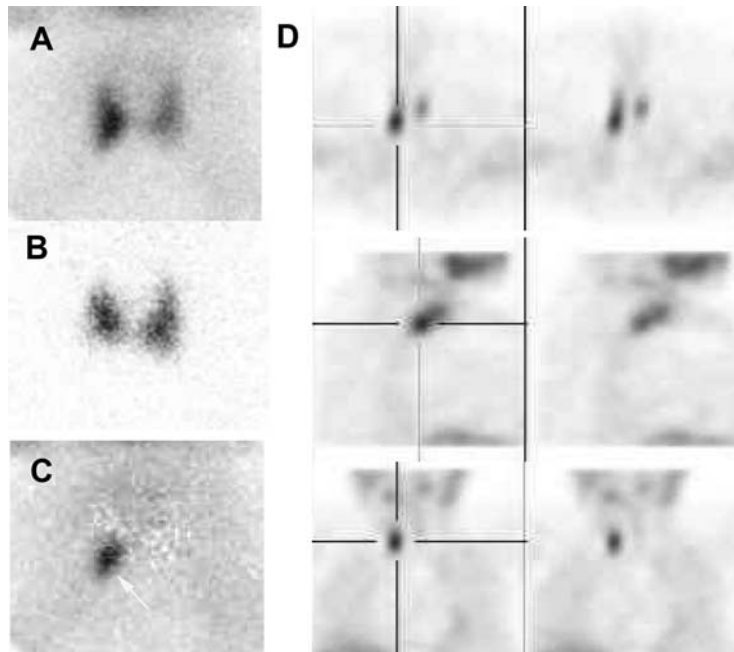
Protocol: injection of 12 MBq of ^{123}I at T-2 h, injection of 740 of $^{99\text{m}}\text{Tc}$ -sestaMIBI at T0, dual tracer planar pinhole acquisition at T + 3 (20 min acquisition), SPECT at T + 45 min (30 s/projection). For SPECT, image was acquired with a 20% window centered over the 140-keV photopeak. Planar pinhole (A: $^{99\text{m}}\text{Tc}$ -sestaMIBI, B: ^{123}I , C: subtraction images) and SPECT images (D) of parathyroid adenomas. The posterior extension of the adenoma on SPECT images is highly suggestive of P4 origin, despite its apparent right inferior origin on planar images (white arrow).
